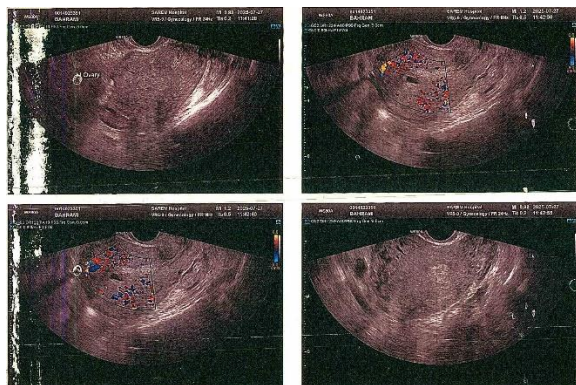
Transvaginal ultrasonographic image of the uterus and left interstitial region demonstrating a hypoechoic mass in the cornual area with increased vascularity on color Doppler examination.
